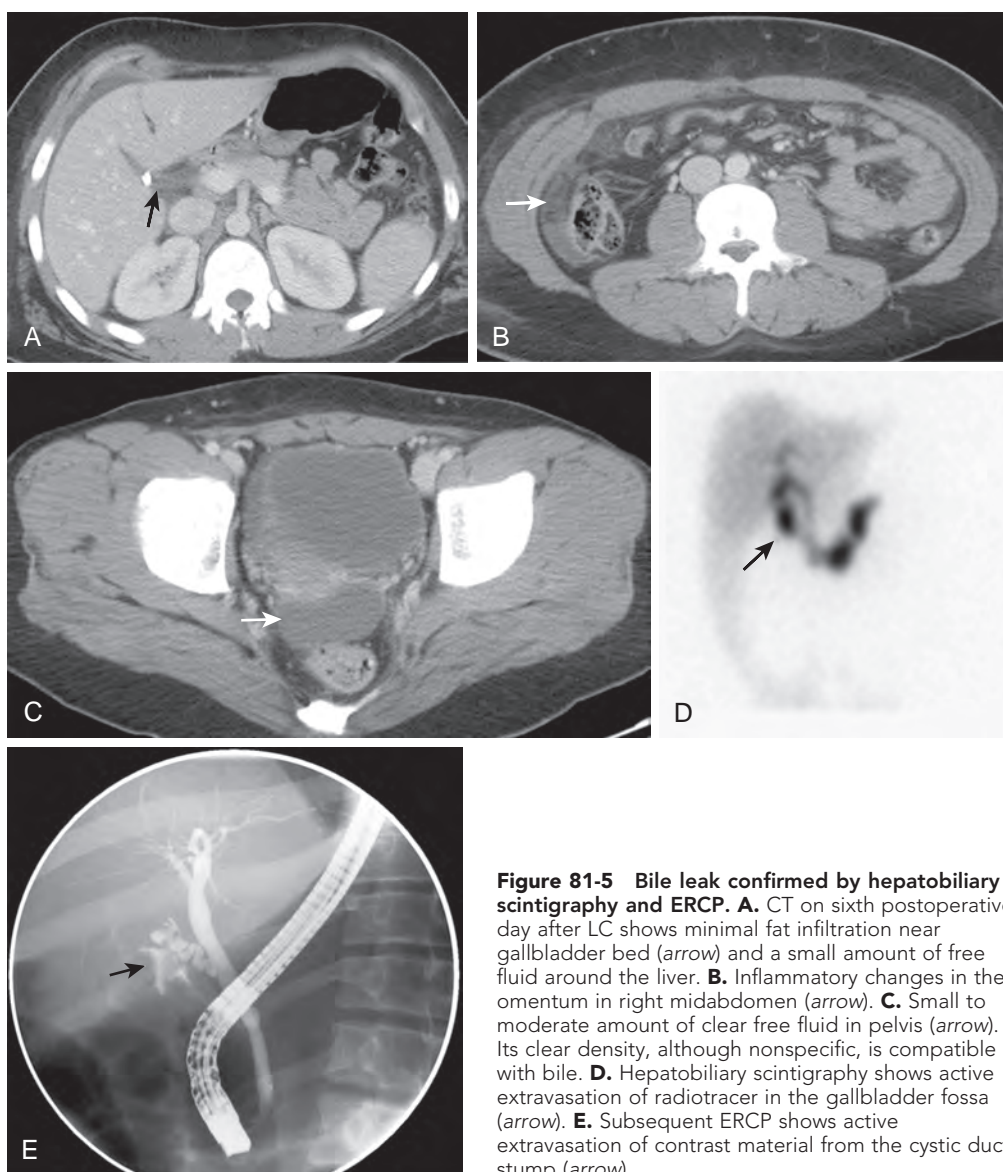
Bile leak confirmed by hepatobiliary scintigraphy and ERCP. A. CT on sixth postoperative day after LC shows minimal fat infiltration near gallbladder bed (arrow) and a small amount of free fluid around the liver. B. Inflammatory changes in the omentum in right midabdomen (arrow). C. Small to moderate amount of clear free fluid in pelvis (arrow). Its clear density, although nonspecific, is compatible with bile. D. Hepatobiliary scintigraphy shows active extravasation of radiotracer in the gallbladder fossa (arrow). E. Subsequent ERCP shows active extravasation of contrast material from the cystic duct stump (arrow).
